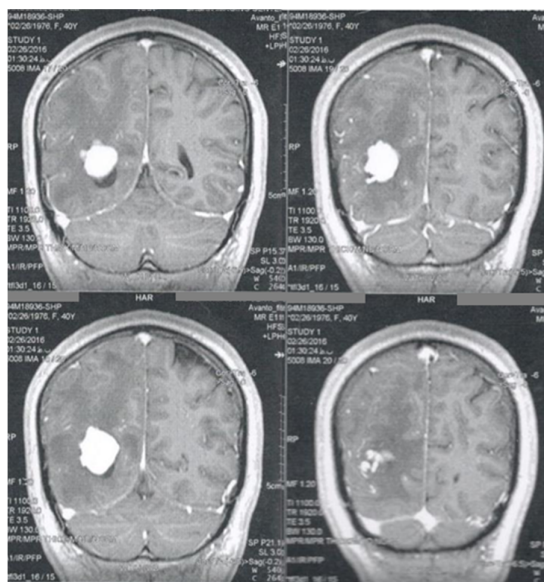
Brain MRI indicating a large mass in the right occipital cortex. Surgery showed the origin of tumor was papillary thyroid cancer.
